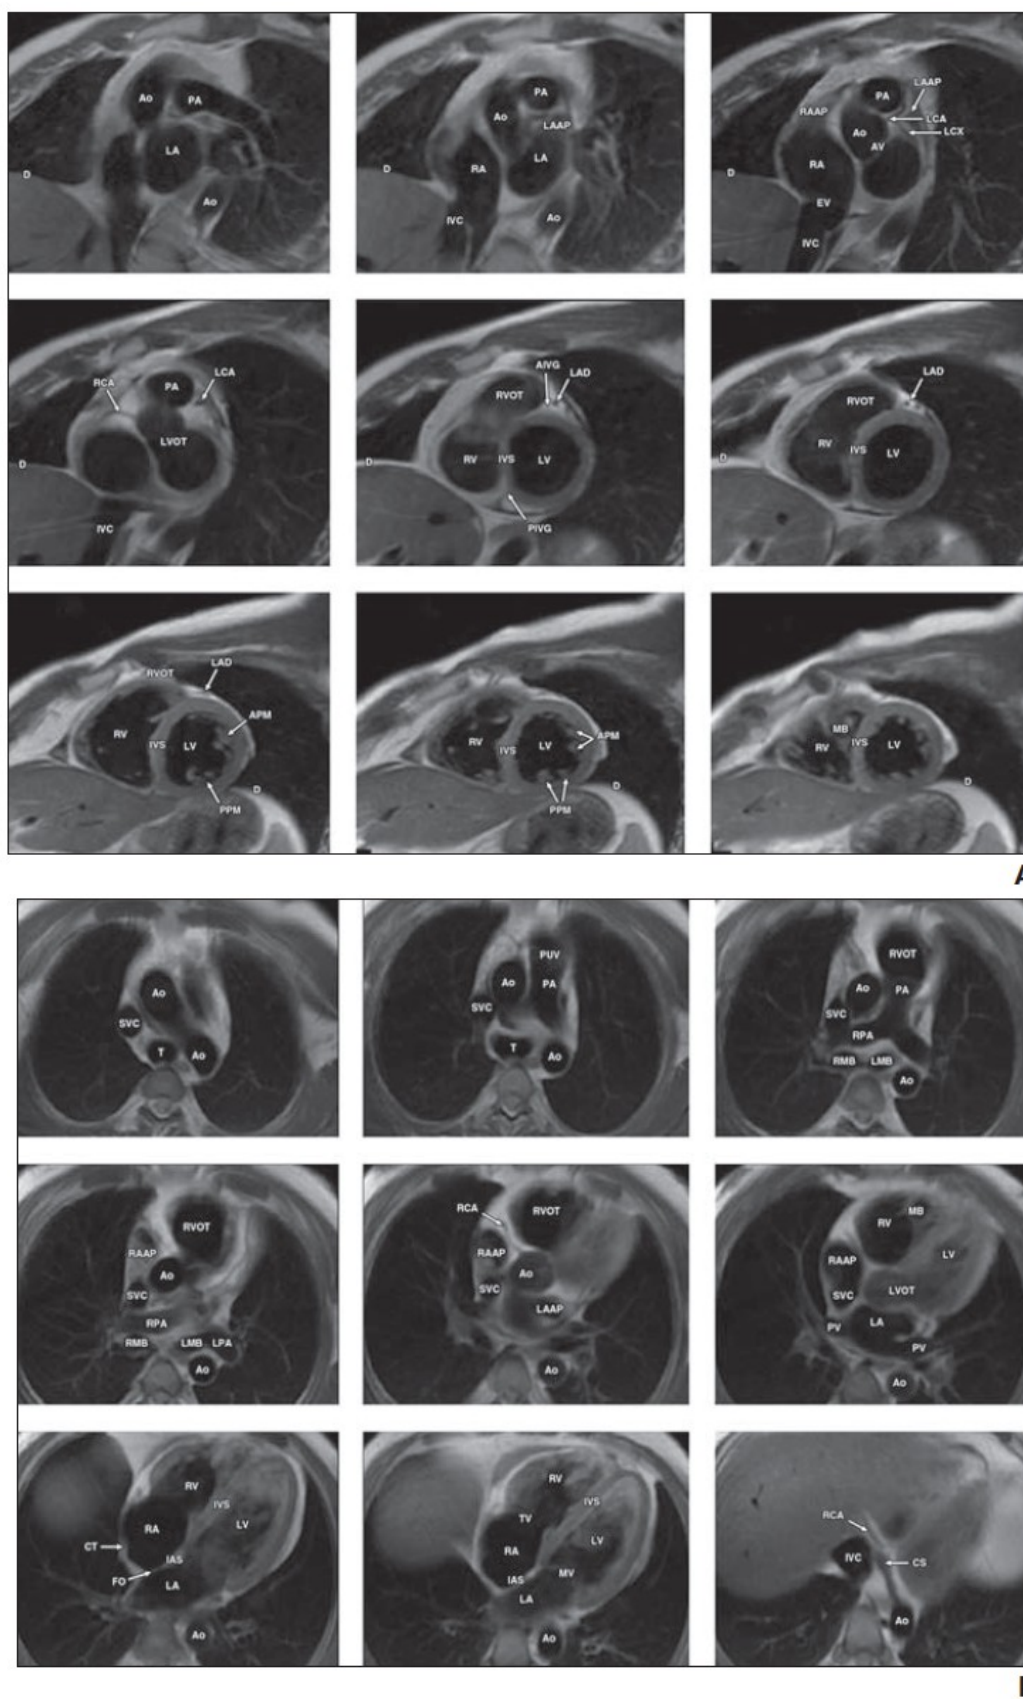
Normal cardiac MRI anatomy. Short-axis (A), horizontal long-axis (B)
